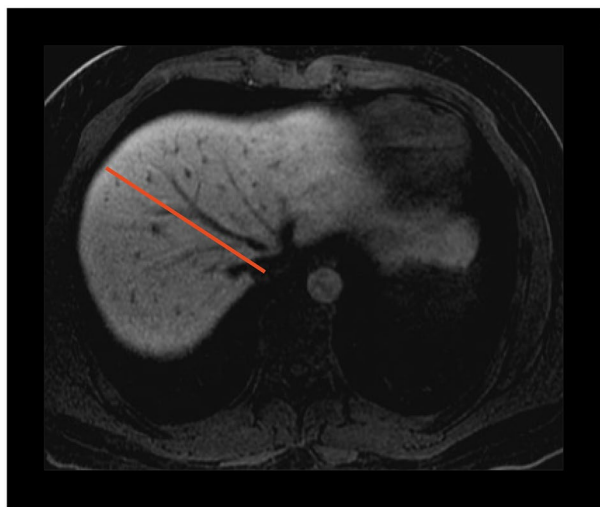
MR image with Cantile imaginary line used to define the standard section plane for right and left lobe volume calculation, drawn about 1 cm to right of the middle hepatic vein
